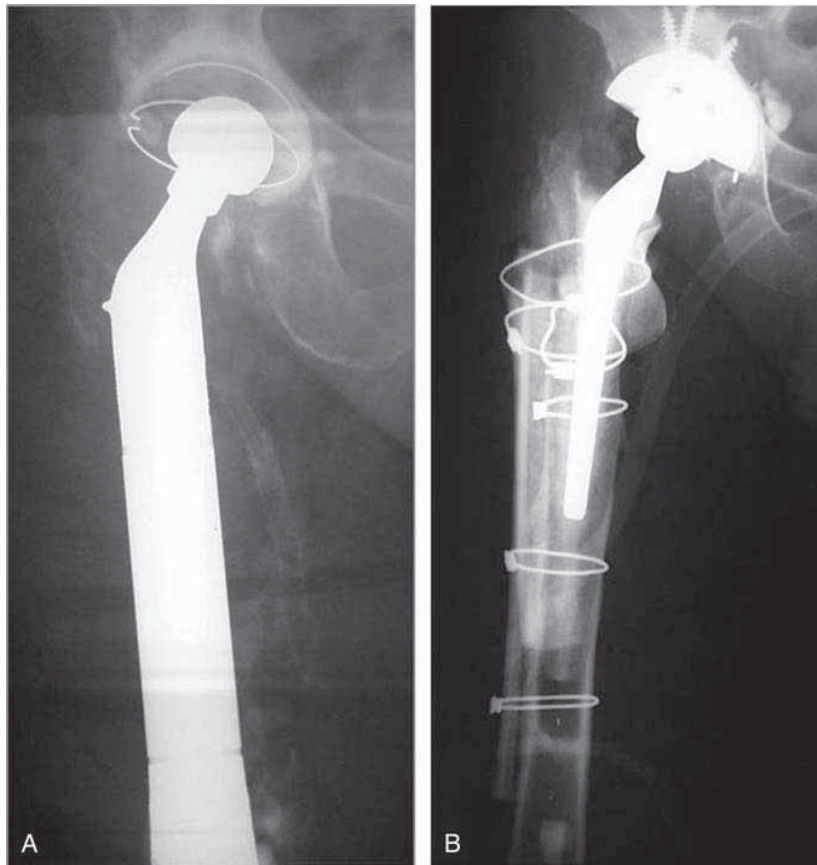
A, Postoperative radiograph of a megaprosthesis used for the second-stage revision of a previously infected THA. B, Postoperative radiograph of the scaffold technique using a modular tapered titanium femoral component augmented with allograft.
